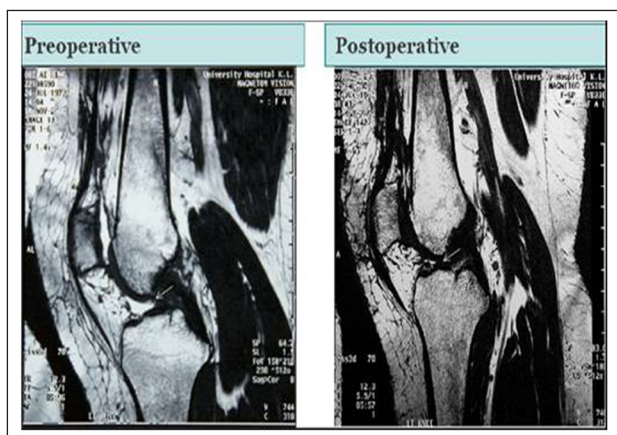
Magnetic resonance images obtained 3 year after autologous chondrocyte implantation preoperatively and postoperatively
